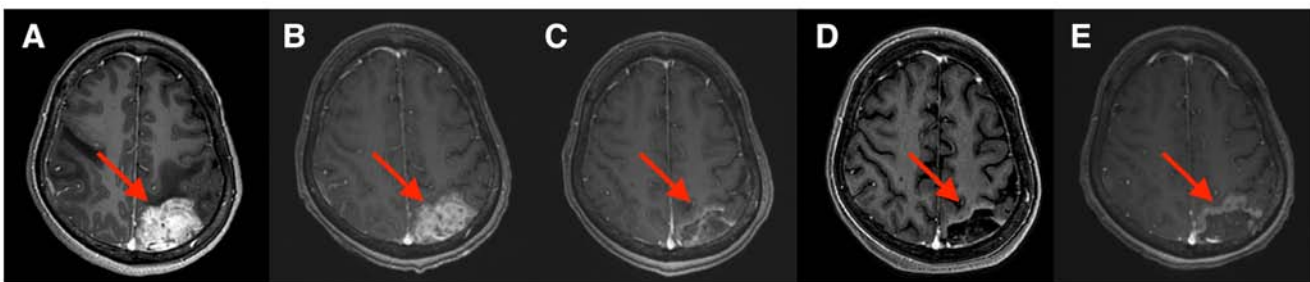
Brain MRIs of response of metastasis of left occipital parietal lobe to apatinib + trastuzumab + albumin-bound paclitaxel. (A) Prior to combination treatment (T1-weighted enhancement), (B) after 2 cycles of combination treatment (T1-weighted BRAVO enhancement), (C) after 4 cycles of combination treatment (T1-weighted BRAVO enhancement), (D) after 6 cycles of combination treatment (T1-weighted enhancement) and (E) after 8 cycles of combination treatment (T1-weighted BRAVO enhancement). The white areas indicated by arrows are left occipital parietal lobe metastases. MRI, magnetic resonance imaging. BRAVO, brain volume imaging.
